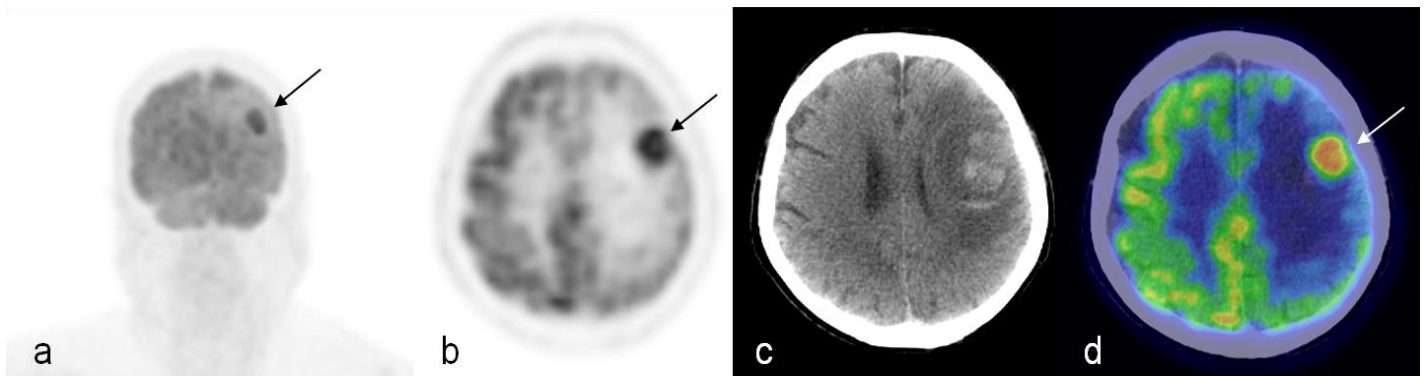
PET/CT performed at initial presentation of MCC
